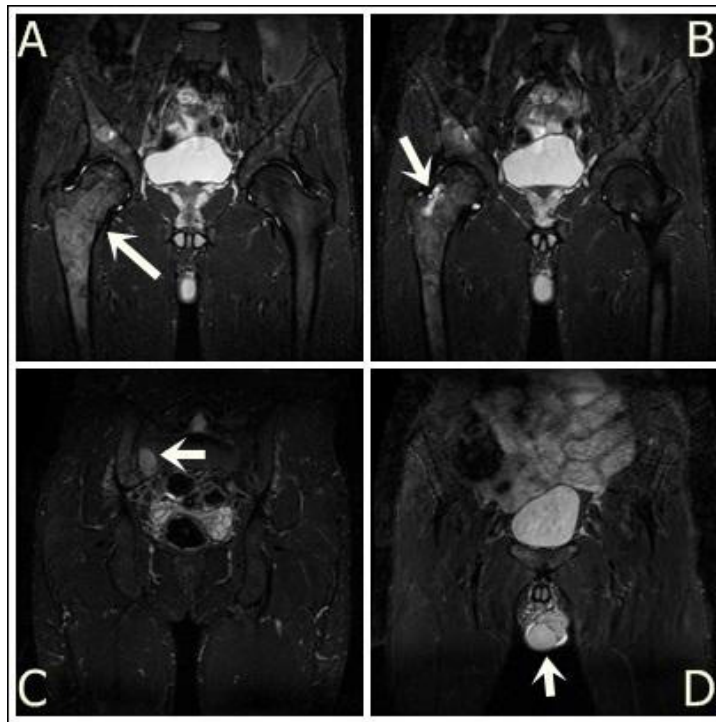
Coronal MRI of the pelvis, STIR sequence. There is diffuse intraosseous abnormality characterized by heterogeneously increased signal (frame A,B,C - arrows) involving the right iliac bone, sacrum adjacent to SI joints, anterior acetabulum, femoral head, neck, metaphysis and diaphysis. The cortex is thinned throughout most of the right femur, with several regions of important cortical thinning. Frame D (arrow) is showing right incidental testicular agenesis found on this MRI, confirming the clinical finding at genital organs examination. A large area of cystic degeneration with fluid-fluid levels (Frame B) is present within the right femoral neck. The cortex surrounding this area is severely thinned. However, no displaced fracture is noted at this site.
